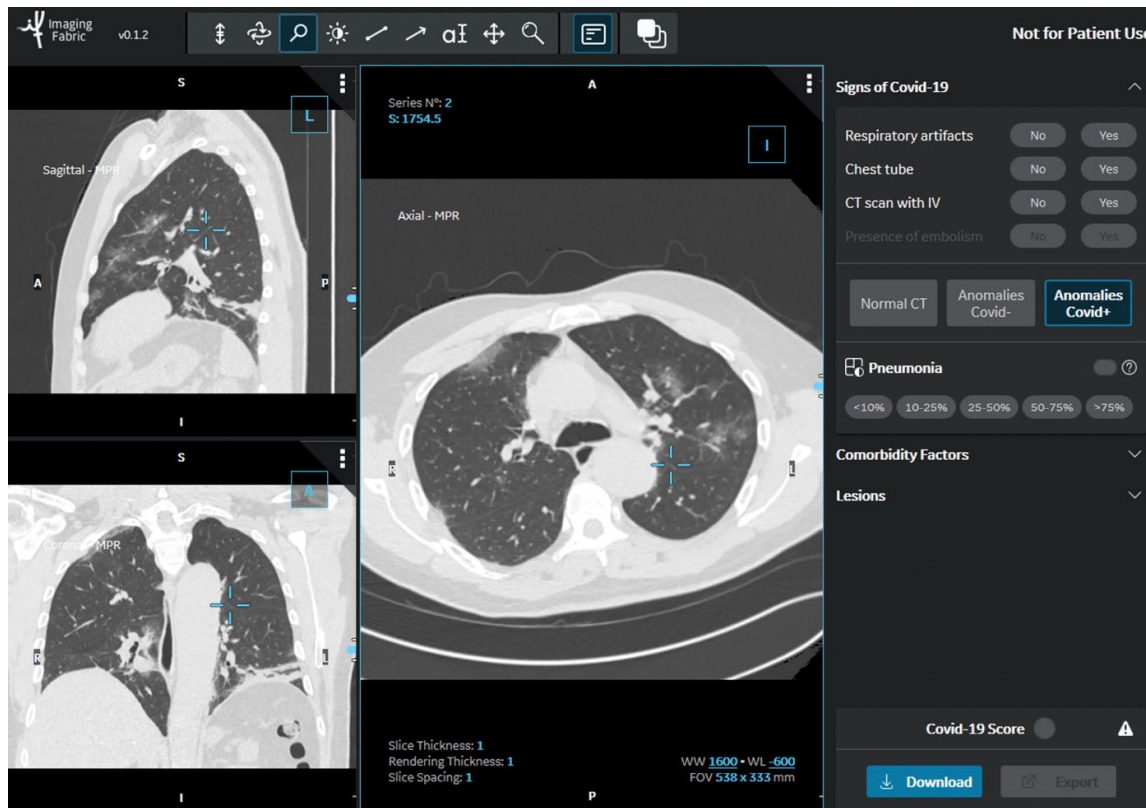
CT annotations: Classification as COVID+, COVID- or Normal CT. The readers had access to the CT scans using a 3D image visualization web application, allowing scrolling through the entire lung volume in the coronal, sagittal, or axial transverse plane. The CT scan shown here has been classified as COVID+, due to the presence of bilateral ground glass opacities and absence of features such as mucoid impaction, bronchiolar nodules, segmental or lobar consolidation.
